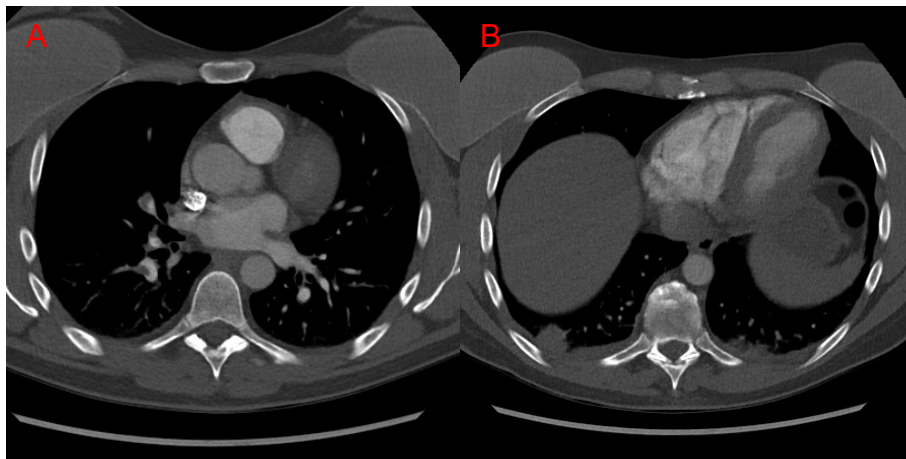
CASE 3: AXIAL CT WITH CENTRAL AND SEGMENTAL PE, SIGNS OF PLEURAL EFFUSION, AND PULMONARY INFARCTION
